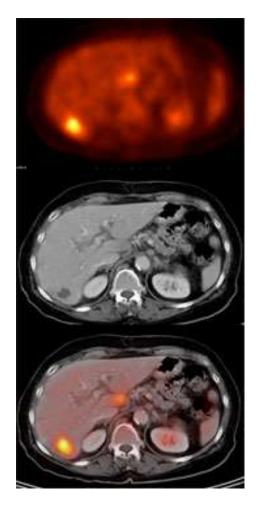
PET image (on top), CT middle, and PET/CT (bottom)
